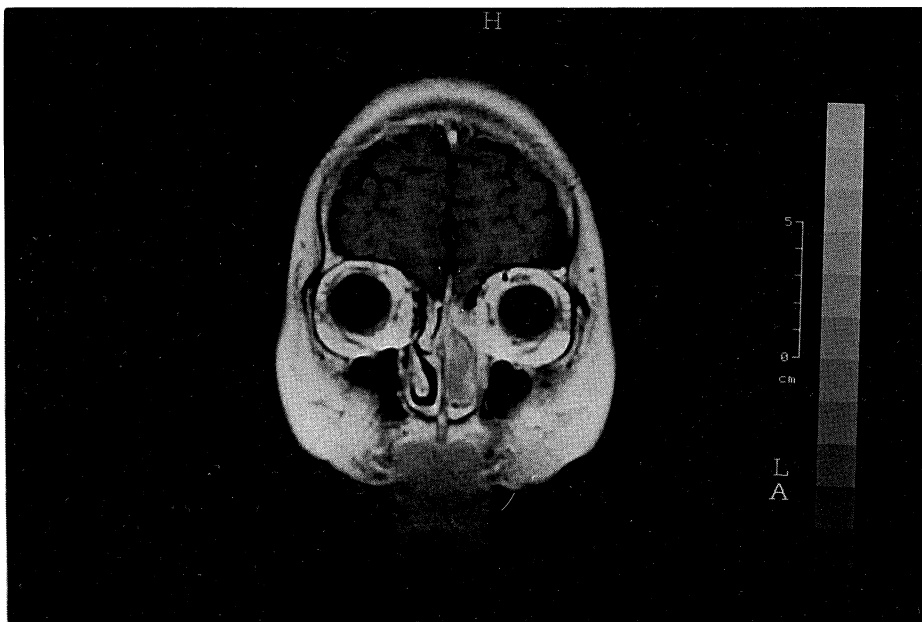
MRI(coronal view) showed a tumor filling the left nasal cavity and ethmoid sinus.
